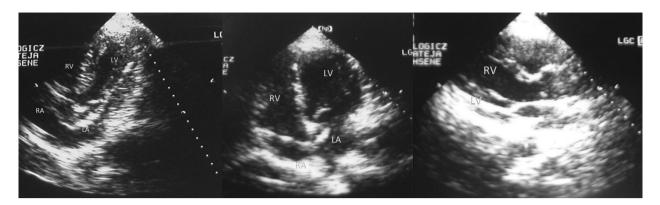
Transthoracic echocardiography before LV lead extraction; LA — left atrium; RA — right atrium; LV — left ventricle; RV — right ventricle
